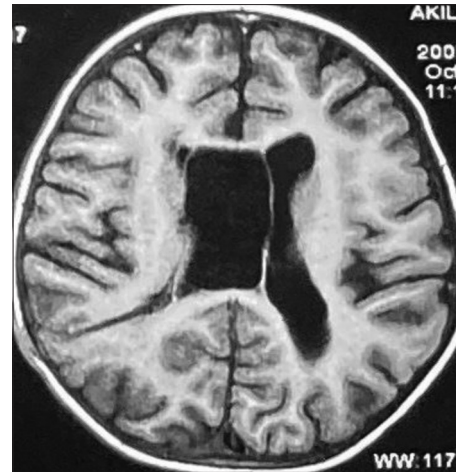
Magnetic resonance imaging T1 axial cuts shows post op right VP shunt
